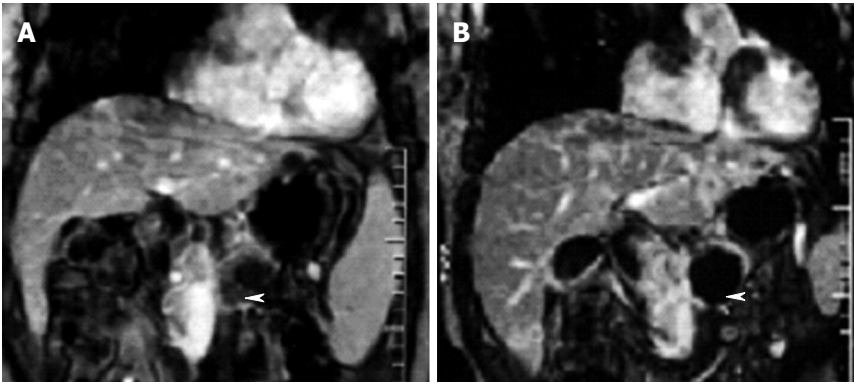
Dynamic contrast-enhanced gradient-echo T1-weighted magnetic resonance images (180/6.0, 90° flip angle, 128 × 256 matrix, 10-mm-thick sections, 2-mm intersection gap, one signal acquired, and 18-s acquisition time) obtained with breath holding in 48-year-old man who underwent high-intensity focused ultrasound ablation for advanced pancreatic cancer. The tumor was 4.5 cm × 4.5 cm in diameter and located in the body of the pancreas. A: Image obtained before high-intensity focused ultrasound shows the blood supply in the pancreatic lesion (arrowhead); B: Image obtained 2 wk after high-intensity focused ultrasound shows no evidence of contrast enhancement in the treated lesion (arrowhead), which is indicative of complete coagulation necrosis in the pancreatic cancer.
